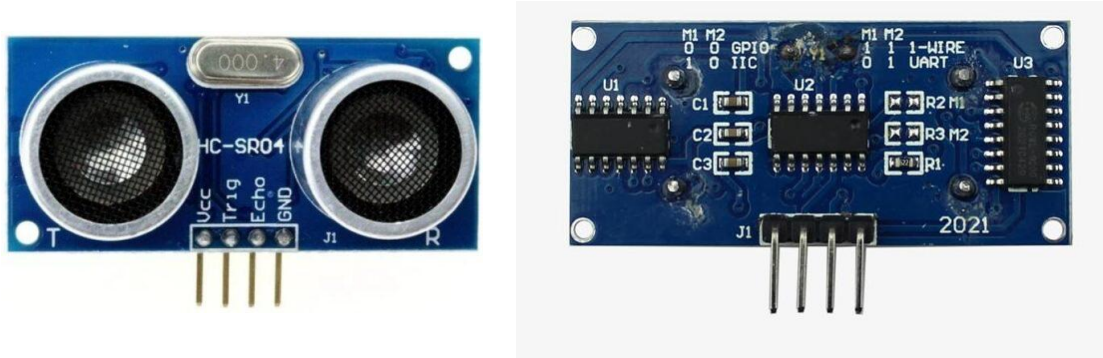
ULTRASONIC SENSOR
